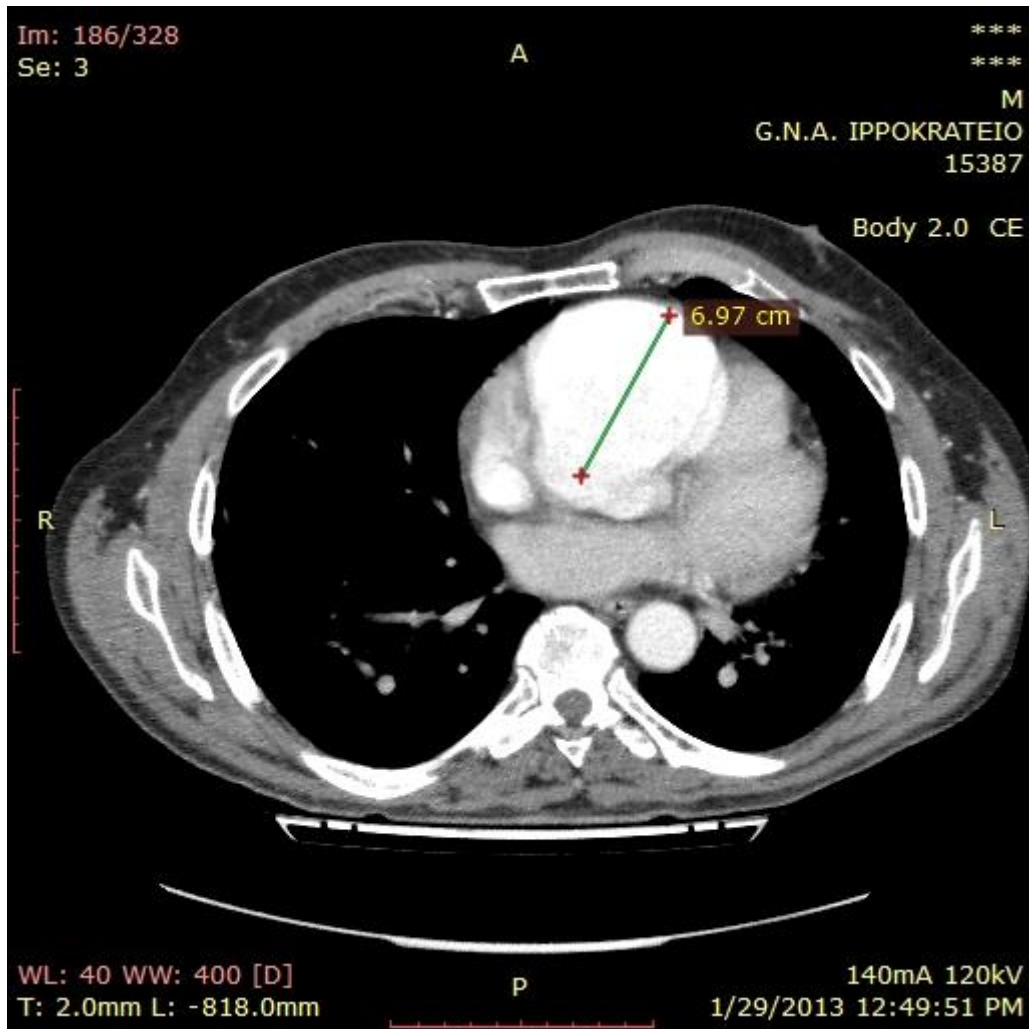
CT slice showing the maximal diameter of the aneurysm extending up to 7 cm.
